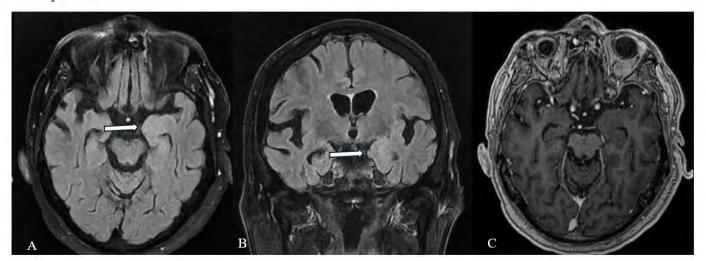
Axial T2 FLAIR (A), Coronal T2 FLAIR (B) and Axial T1 Post Contrast (C) images demonstrate a mildly expansile lesion centered in the left amygdala and extending into the left pyriform cortex without corresponding enhancement.
